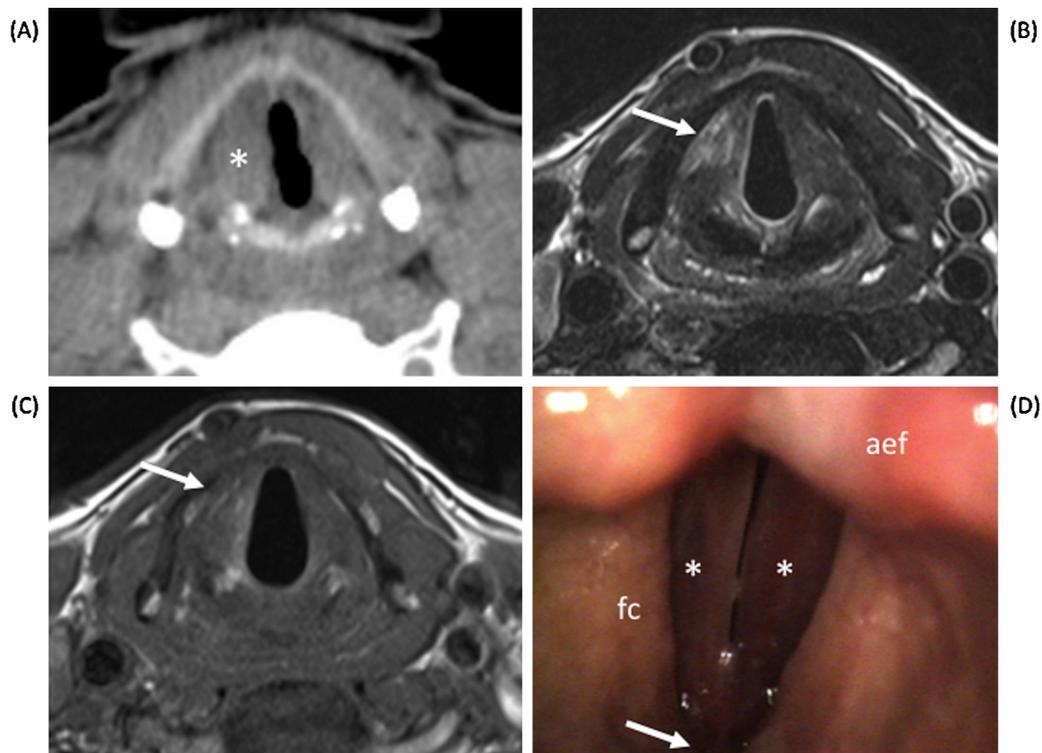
Glottic hematoma, as seen on MDCT and MRI in the acute trauma setting. Axial CT image at the glottic level (A) shows slight enlargement of the right vocal cord (asterisk) and no obvious difference in attenuation values between both cords. Axial T2w (B) and T1w (C) images obtained at the same level clearly show hematoma involving the right thyroarytenoid muscle and the right paraglottic space (arrows). The hematoma has high signal intensity on both sequences due to the presence of methemoglobin. The left vocal cord looks normal. (D) Flexible endoscopy (view from above during phonation) reveals bilateral hematoma (asterisks) and normal vocal cord mobility. aef, left aryepiglottic fold; fc, right false cord. Arrow points at the normal anterior commissure.
